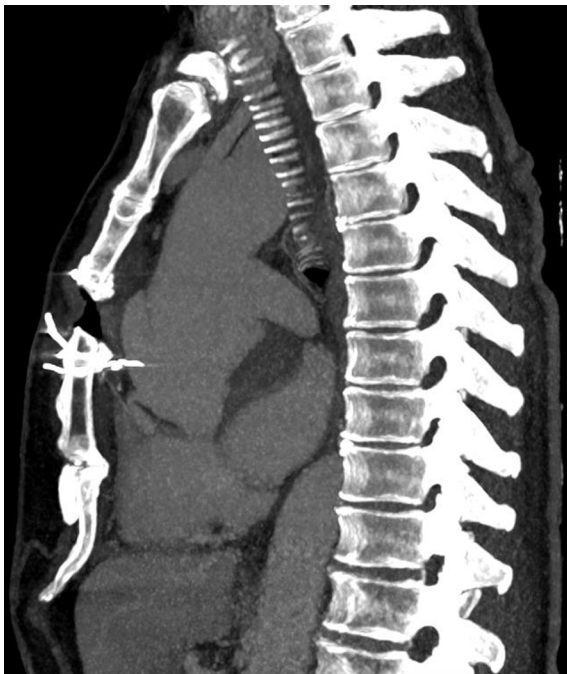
Thoracic aorta CT angiography (sagittal MIP reconstruction) showing a type A dissection flap extending from the aortic root to the aortic arch, adjacent to the displaced sternal suture fragment.
